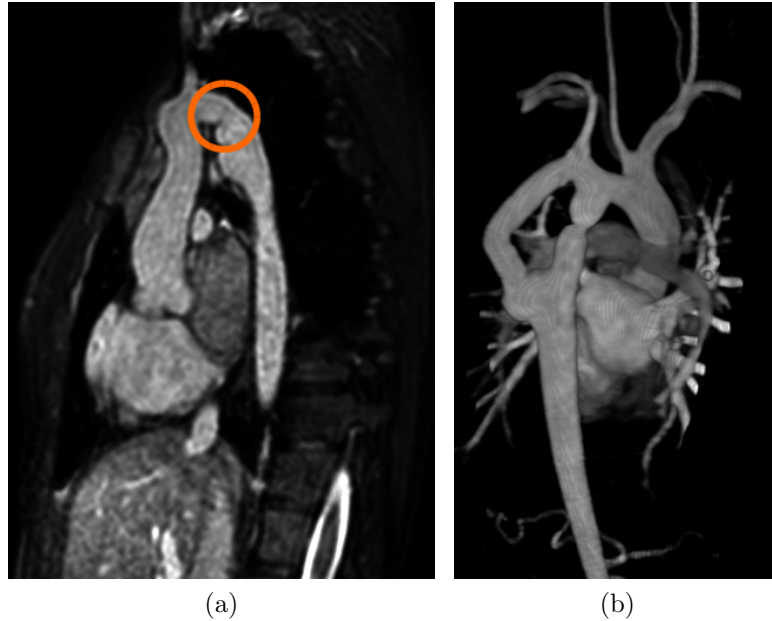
a) Coarctation of the aorta (CoA) as shown on 3D cardiac MR volume (circled); b) Volumetric reconstruction of MRI showing a pathological aortic isthmus, where a collateral bypass had developed around the narrowing of the CoA.
